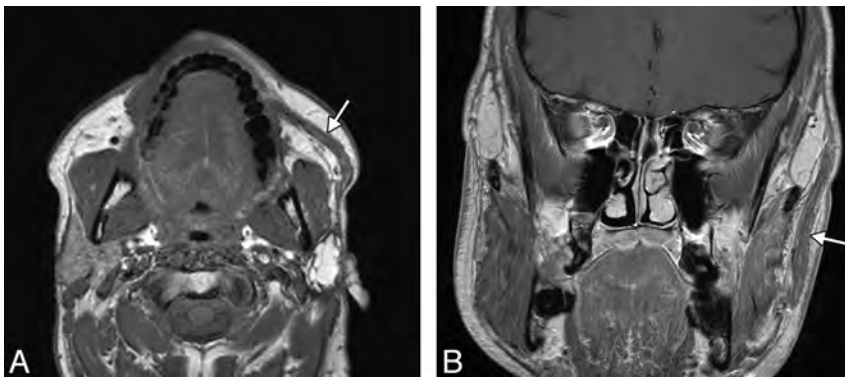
Gracilis free flap. Axial (A) and coronal (B) postcontrast T1-weighted MR images show a healthy gracilis flap (arrows), which extends from the zygomatic arch to the oral commissure following total left parotidectomy, with facial nerve sacrifice for resection of mucoepidermoid carcinoma.
